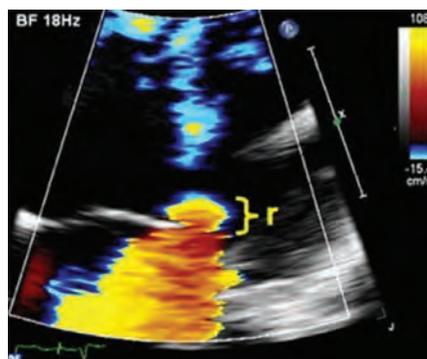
PISA radius (r), apical 4-chamber view.
